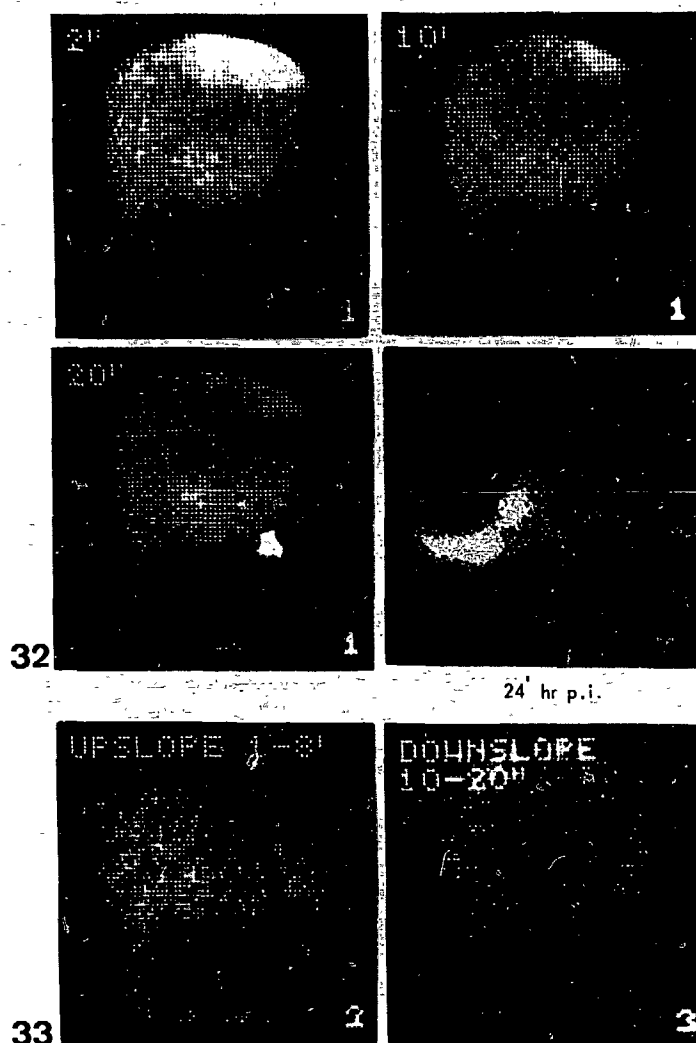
32-33 Cholescintigraphy in a patient with alcoholic hepatitis.
